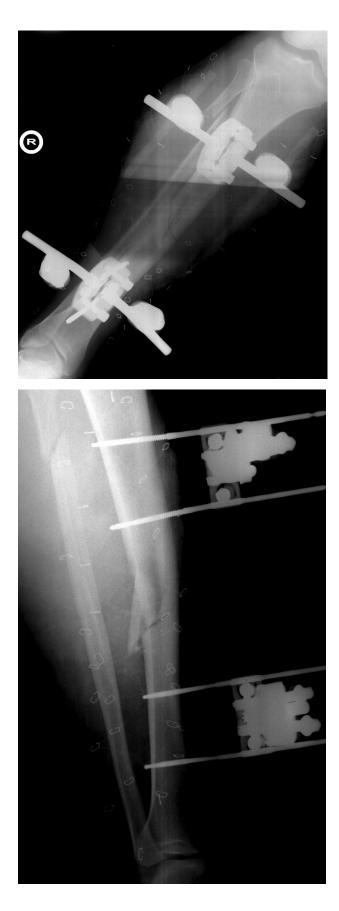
AP* (Top Left) *and lateral* (Bottom Left) *radiographs of right leg with external fixator in place.*
